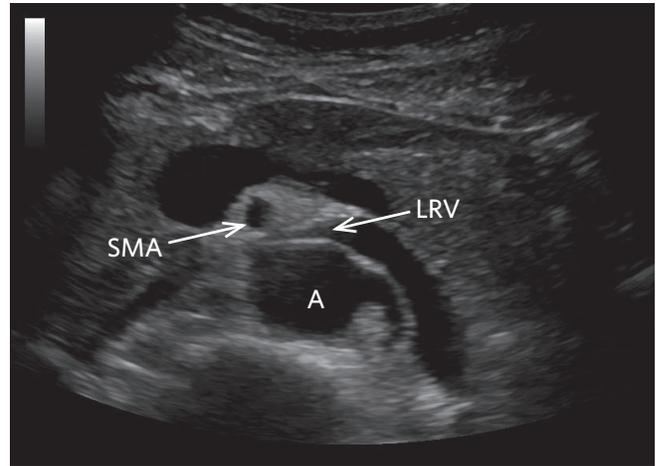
Duplex ultrasound showing compression of the left renal vein (LRV) between the aorta (A) and superior mesenteric artery (SMA).
